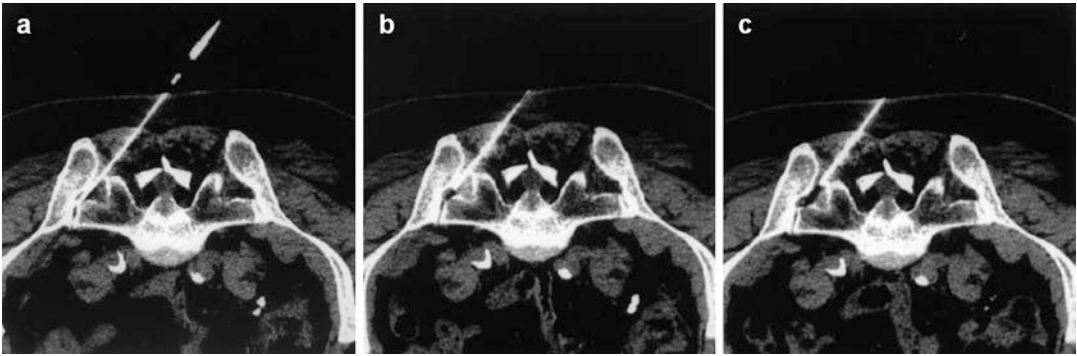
(a–c) CT image of positioning of the cannula. (a) Cannula is placed in ventral portion of ligamentous SIJ component. Then, it is withdrawn by 5 mm to produce an overlapping lesion (b, c) (Gevargez et al. [23])
